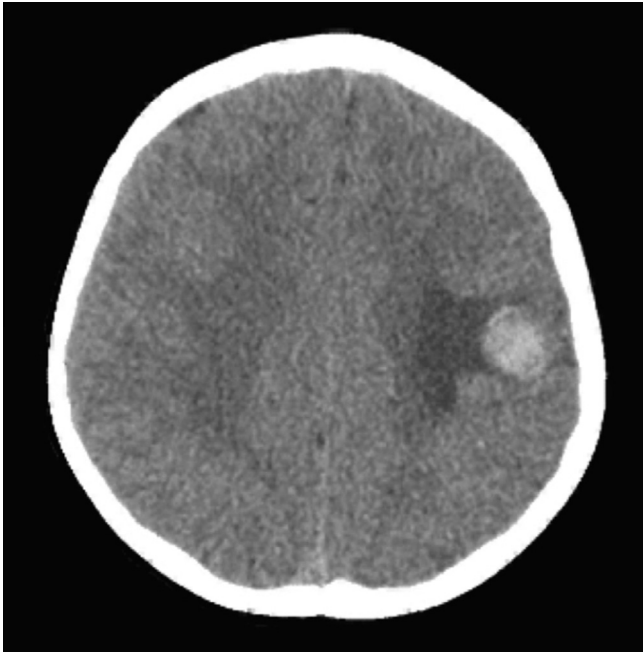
Non-contrast axial CT head scan showing a left fronto-parietal hyperdensity with surrounding hypodensity in the white matter concerning for a hemorrhage with surrounding edema.
